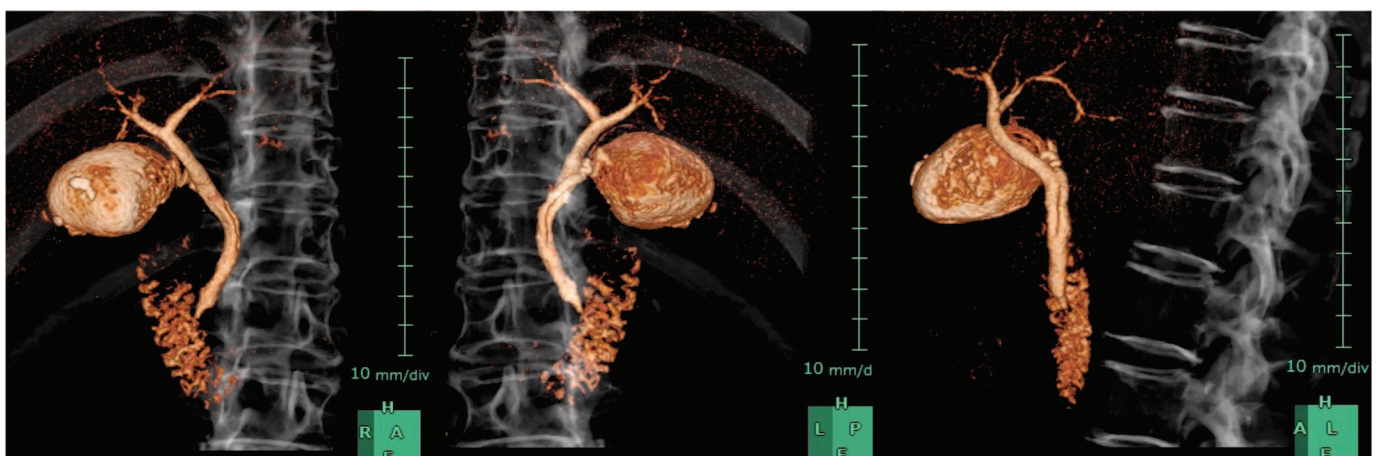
Three-dimensional drip infusion cholecystocholangiography-computed tomography.
